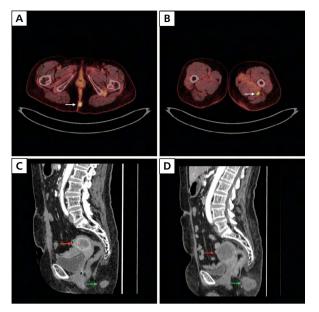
A. Positron emission tomography-computed tomography scan (axial plane) demonstrating intramuscular metastasis to the left thigh area (white arrow); B. Positron emission tomography-computed tomography scan (axial plane) demonstrating intramuscular metastasis to the left buttock (white arrow); C. Computed tomography scan (sagittal plane) demonstrating a ring-shaped contrast-enhanced lesion, adjacent to the sigmoid colon, uterus and small intestine loop (red arrow) and an intramuscular metastasis to the left buttock (green arrow); D. Computed tomography scan (sagittal plane) demonstrating a progressed ring-shaped contrast-enhanced lesion, adjacent to the sigmoid colon, uterus and small intestine loop (red arrow) and an intramuscular metastasis to the left buttock (green arrow)
